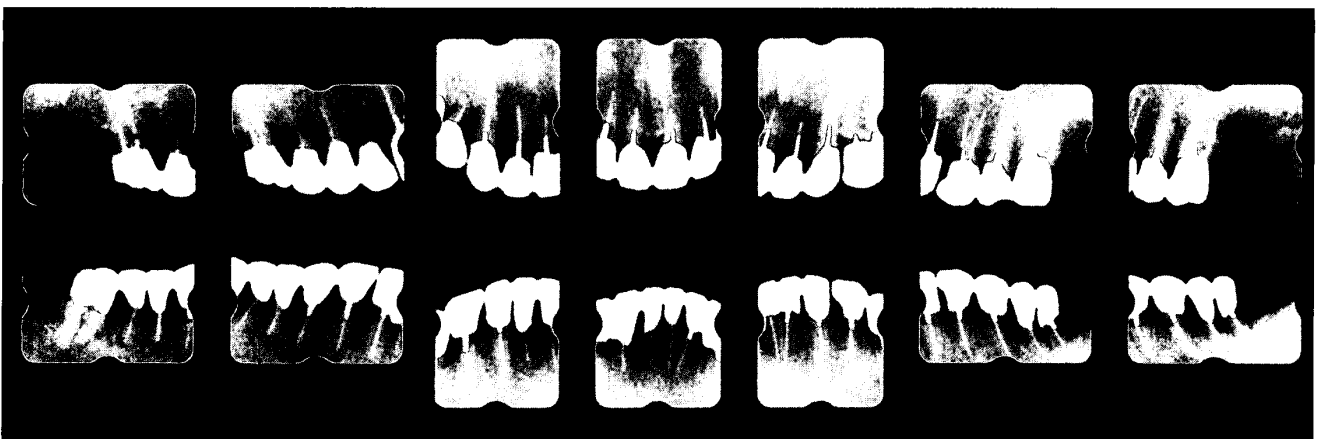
X-ray findings at about 9 years after first medical examination. Improvement of alveolar bone level and the condition was observed in comparison with Fig. 2 at first visit.
